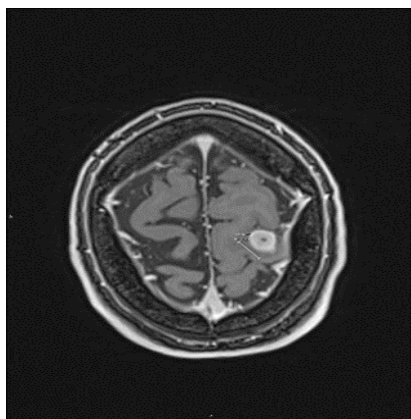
MR of cerebrum June 2019 with intravenous contrast agent. Showing progressive regression of the abscess compared to the initial MRI scanning (lesion diameter 13,0 mm).
